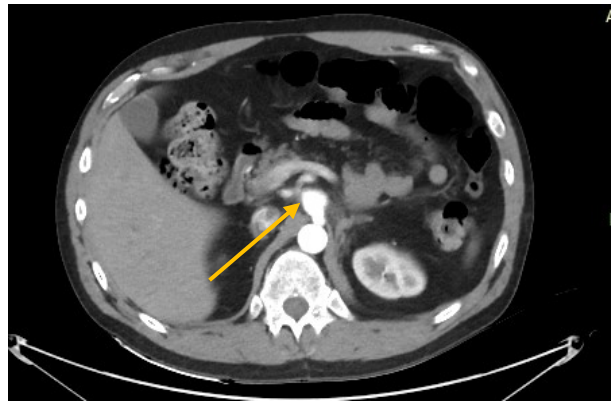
Multi-detector computed tomography angiography – an aneurysm of the coeliac trunk with surrounding contrast extravasation, indicating rupture.
